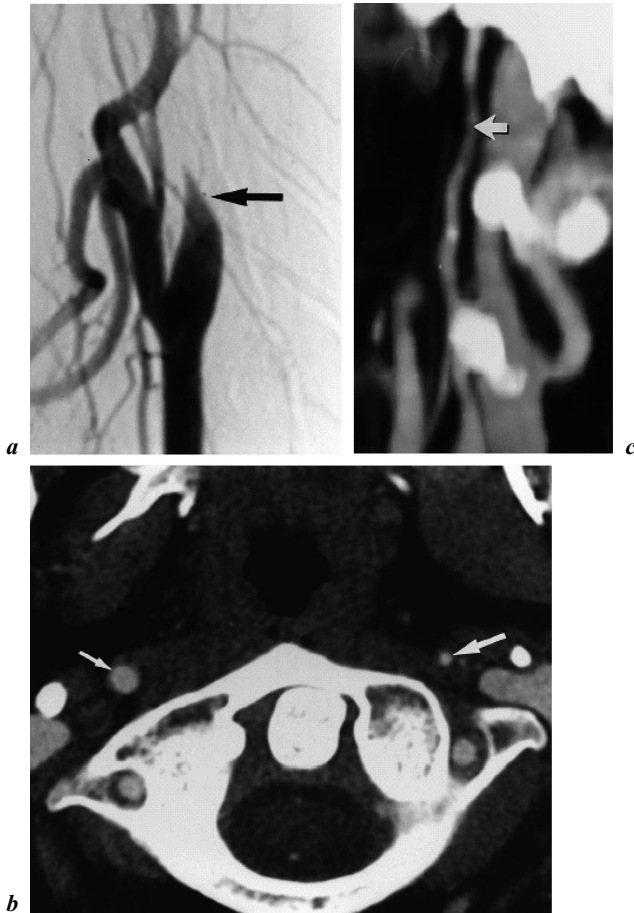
a* Conventional angiogram 2 days after onset of symptoms reveals complete occlusion of the left ICA with tapered lumen just beyond the bulb (arrow). *b* Axial CT scan 3 years later shows a smaller diameter of the left ICA (large arrow) as compared with the contralateral side (small arrow). *c* MIP reconstruction shows a severe narrowing throughout the cervical left ICA (arrow).
